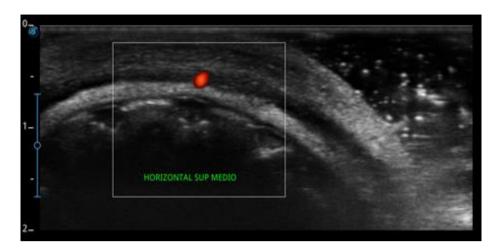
Region of the UMP, using ultrasound with Doppler tool, featuring a horizontally positioned transducer, highlighting the SLA in the IM region
